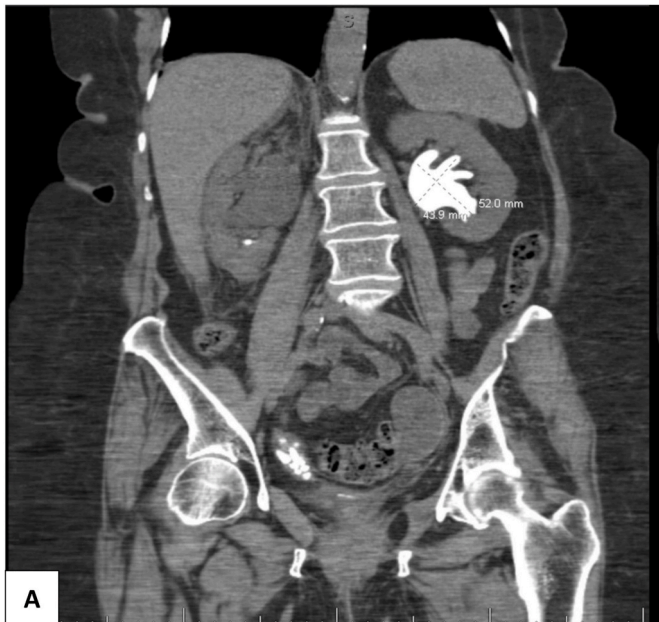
CT Abdomen (Coronal View): Left complete staghorn calculus.
